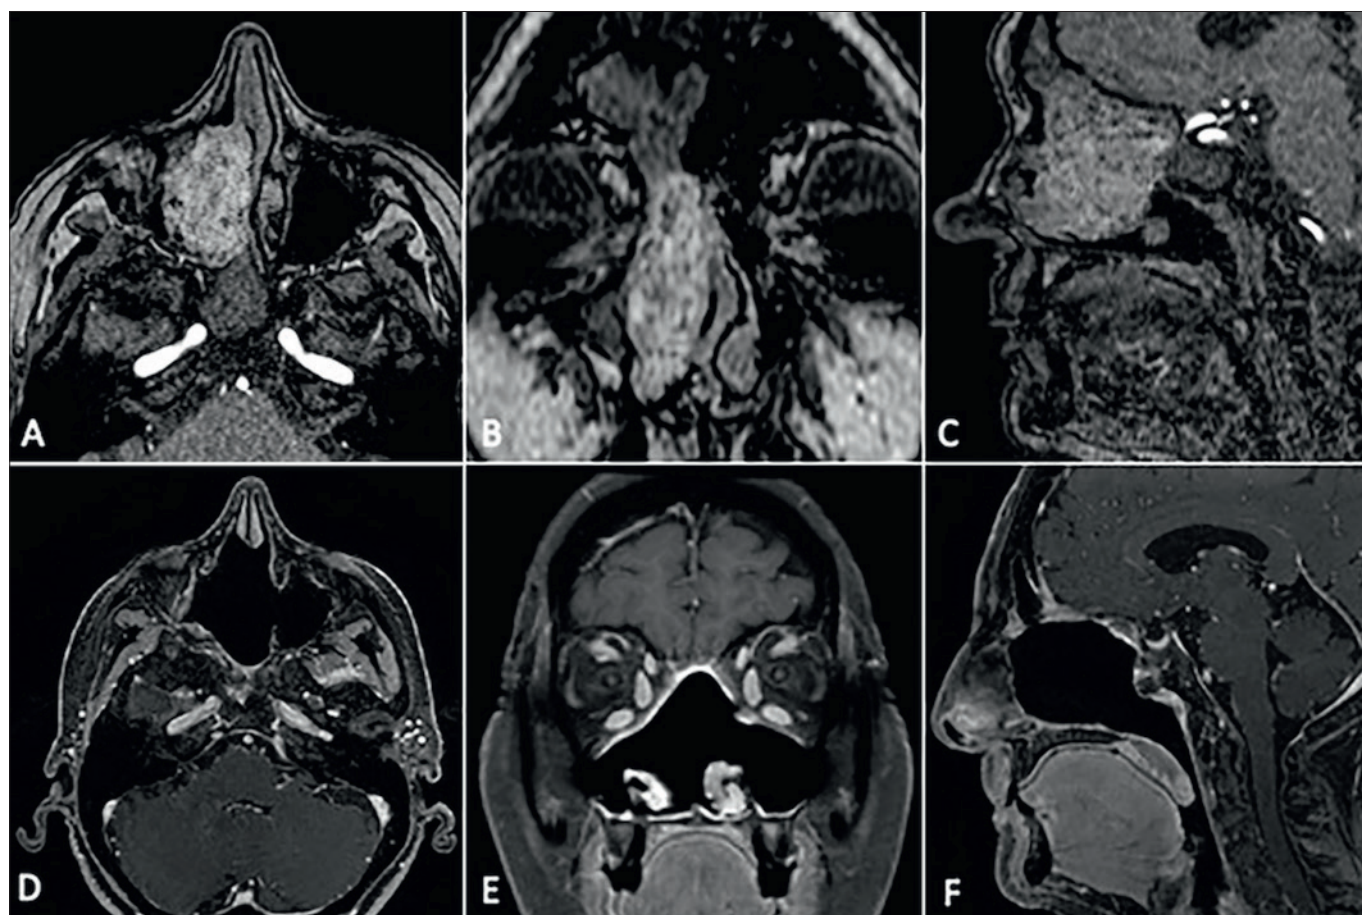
Preoperative MR angiography in axial (A), coronal (B) and sagittal (C) views revealed a mass arising from the right ethmoid. At 45 months, postoperative MRI in axial (D), coronal (E) and sagittal (F) views revealed no recurrence of disease.
